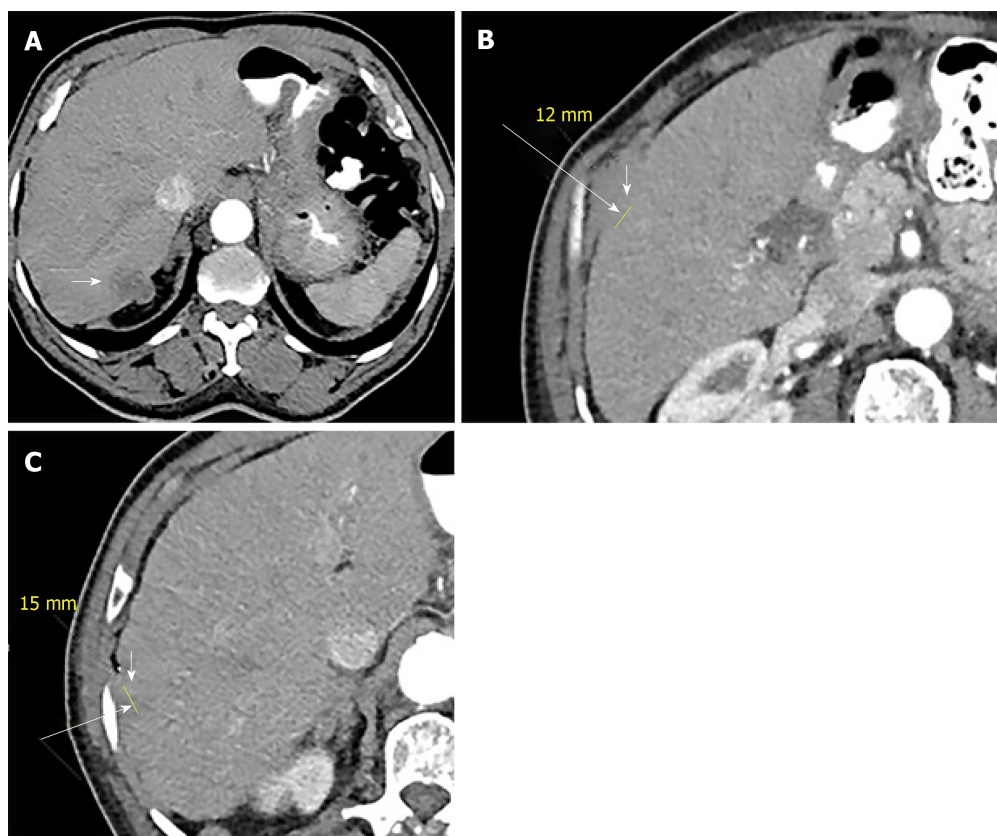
Axial sequential abdominal contrast enhanced computed tomography images (A-C) depict 3 new hepatic lesions in the right lobe (white arrows).
